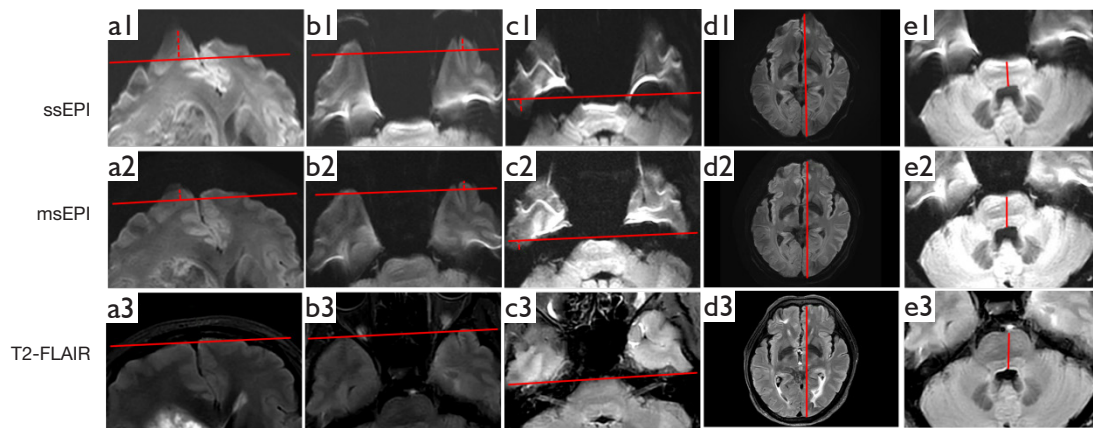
The measurement of distortion displacement between DWI sequences and T2-FLAIR in the (a1-a3) prefrontal lobe, (b1-b3) anterior temporal lobe, (c1-c3) posterior temporal lobe, (d1-d3) brain diameter, and (e1-e3) brainstem diameter. Reference lines (solid lines) were first drawn on T2-FLAIR and copied to the same site on DWI images, and then the displacement between DWI and T2-FLAIR (dashed lines) was measured. In the image in d1-d3 and e1-e3, the diameters were marked by solid lines, and the difference of measurements between DWI and T2-FLAIR was calculated. ssEPI, single-shot echo-planar imaging; msEPI, multishot echo-planar imaging; T2-FLAIR, T2-weighted fluid-attenuated inversion recovery; DWI, diffusion-weighted imaging.
